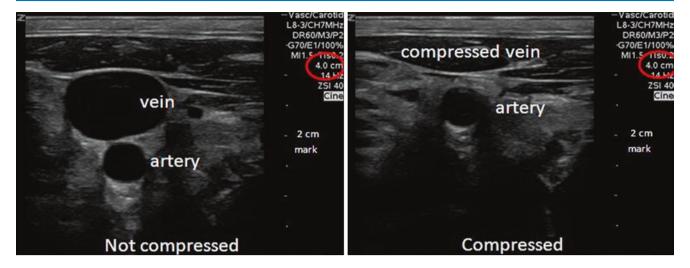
Ultrasound showing internal jugular vein and artery with and without compression
